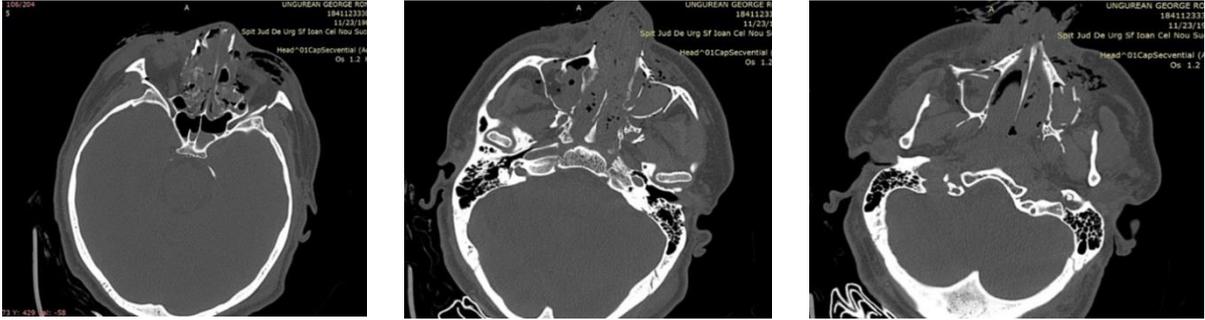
CT Preoperative Aspect
